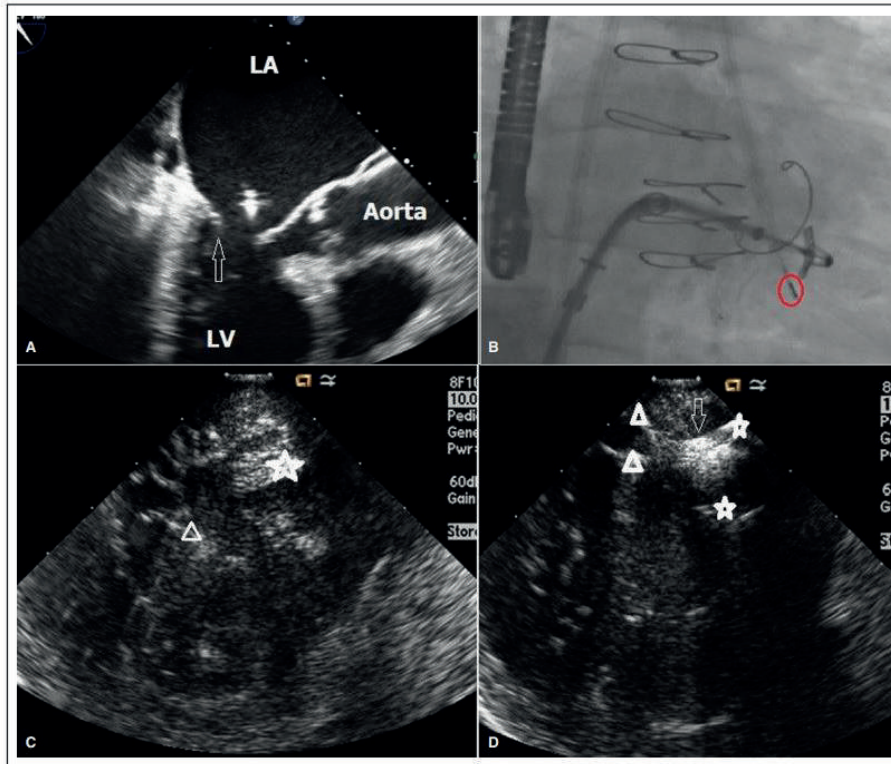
Additional value of intracardiac echocardiography in the visualization of both mitral valve leaflets.
